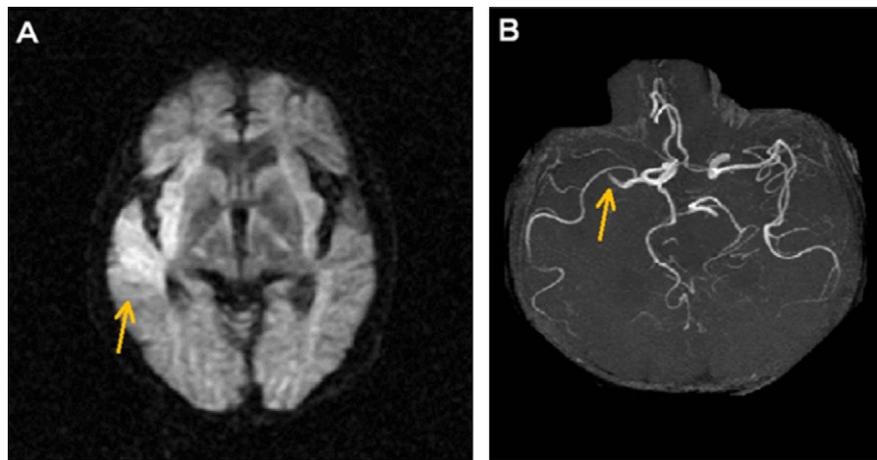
Magnetic resonance imaging at the onset of cerebral stroke. The right temporo-occipital lobe was highly diffused on diffusion-weighted magnetic resonance image (A). The upper trunk of the right middle cerebral artery was occluded on magnetic resonance angiography (B). Arrowheads indicate regions of interest.
